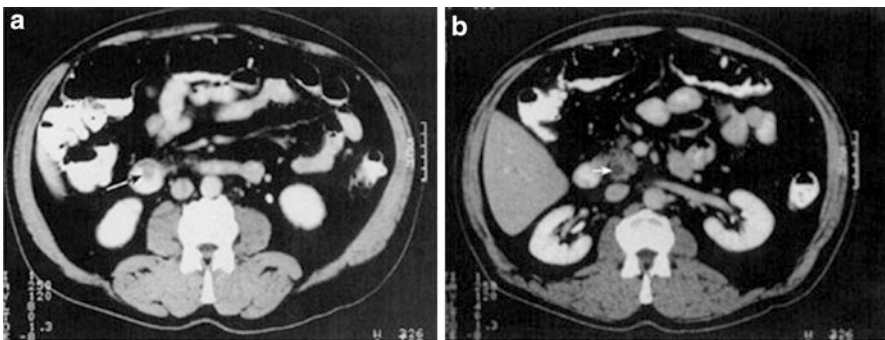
Computed tomography scan of a patient with obstructive jaundice due to ampullary carcinoma: (a) Scan demonstrated a 3-cm ampullary mass (*black arrow*) and (b) scan at higher level demonstrating bile duct dilation within pancreatic parenchyma indicating distal duct obstruction (*white arrow*)
